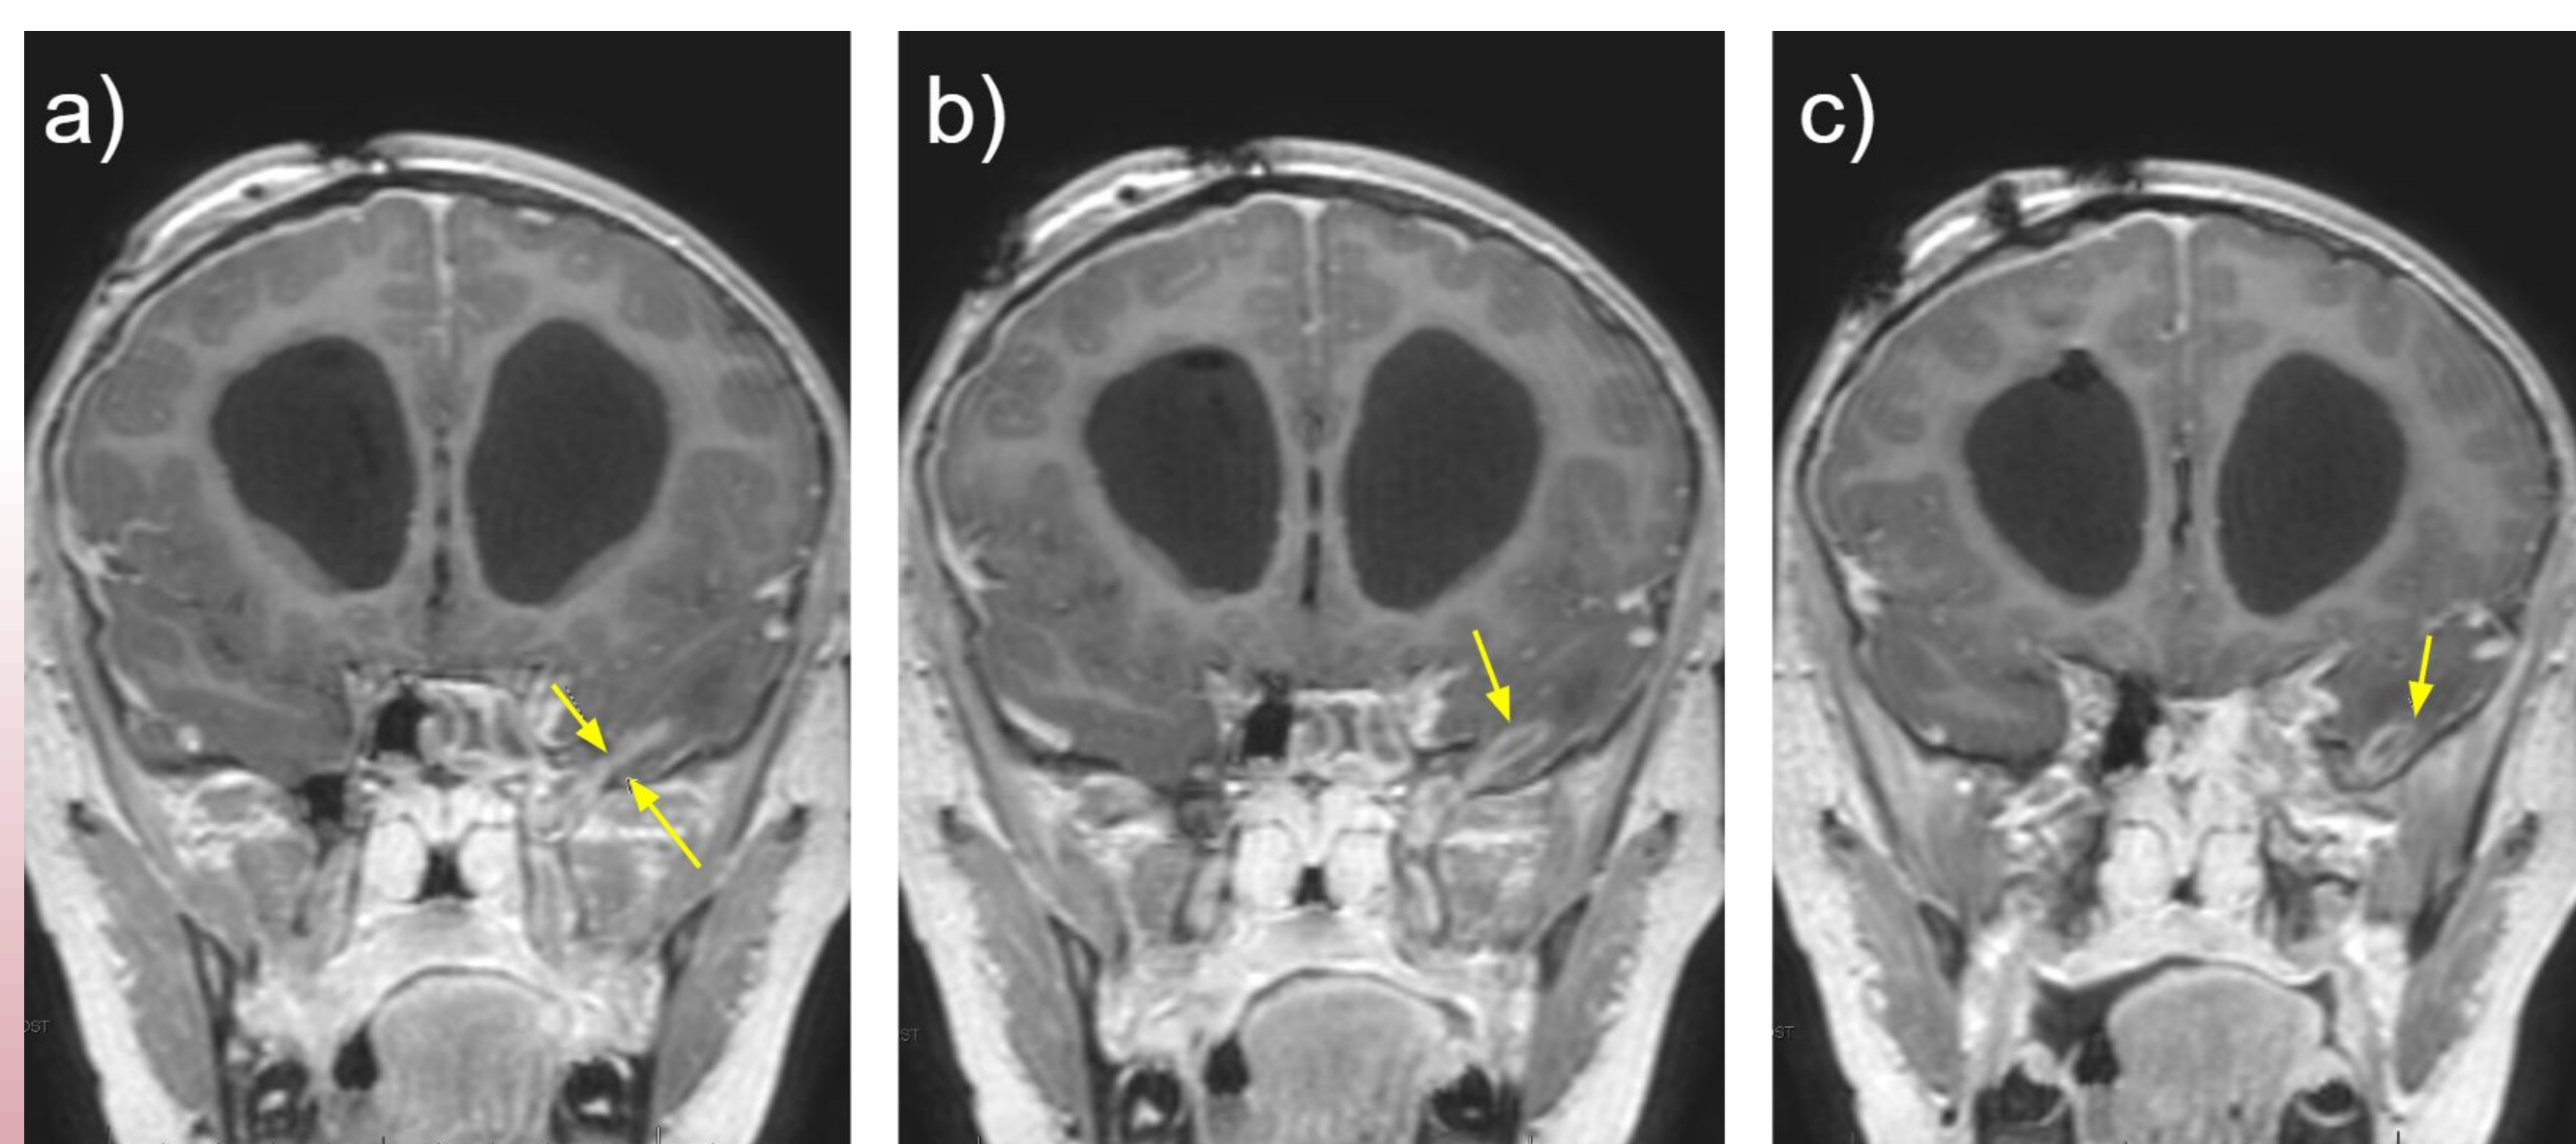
Contrast-enhanced coronal SPGR MRI images demonstrating (a-b) sphenoid sinus infection communicating with (c) a temporal lobe ring-enhancing lesion concerning for abscess. Abbreviations: SPGR = spoiled gradient recalled echo
